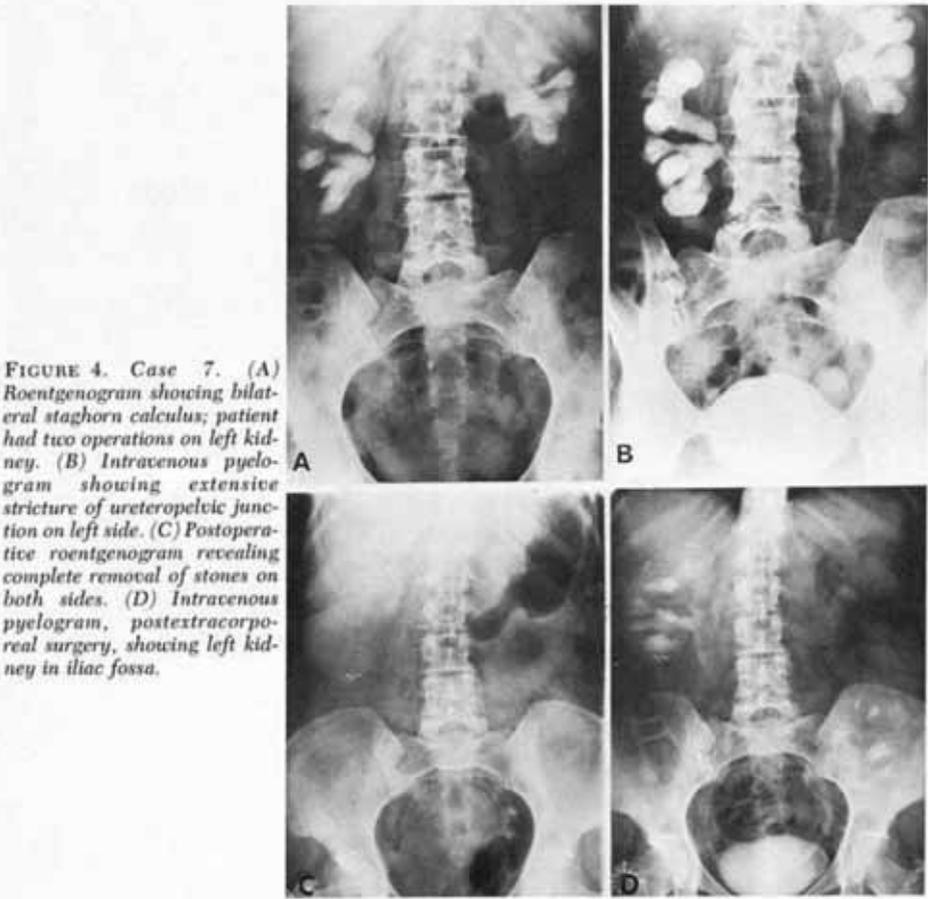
Case 7. (A) Roentgenogram showing bilateral staghorn calculus; patient had two operations on left kidney. (B) Intravenous pyelogram showing extensive stricture of ureteropelvic junction on left side. (C) Postoperative roentgenogram revealing complete removal of stones on both sides. (D) Intravenous pyelogram, postextracorporeal surgery, showing left kidney in iliac fossa.
